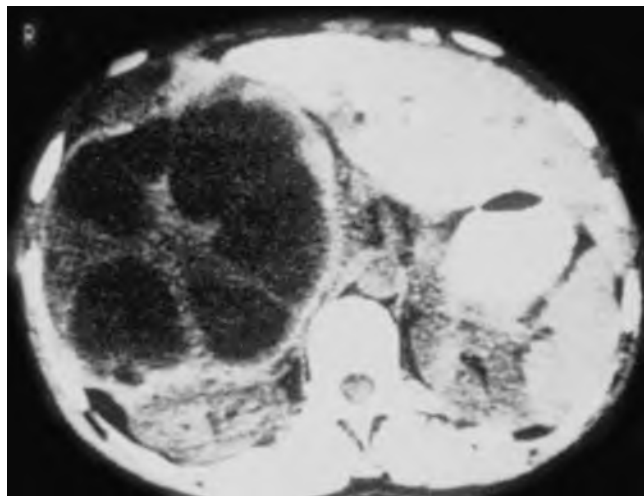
Hydatid cysts of the liver detected on computed tomography scan. Note the well-demarcated wall and characteristic septate internal structures (daughter cysts).
